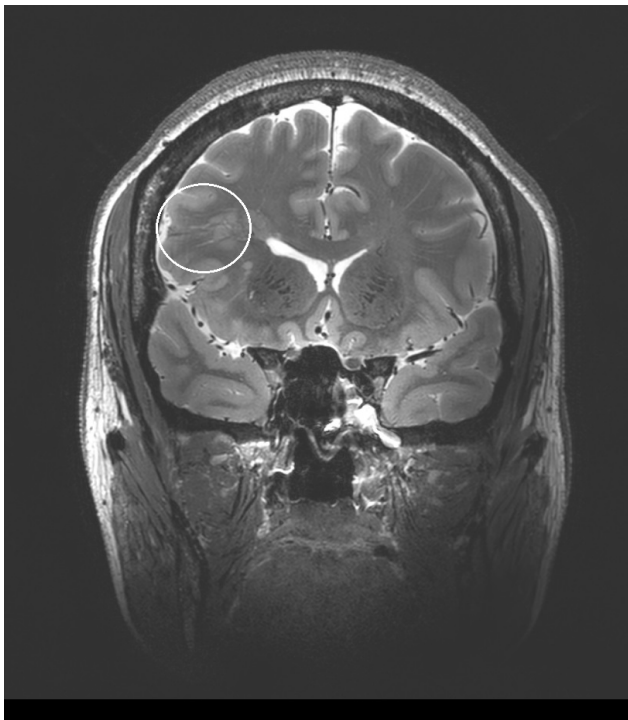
Coronal T2-weighted image at 7T MRI showing a connection between periventricular heterotopia and overlying cortex.
